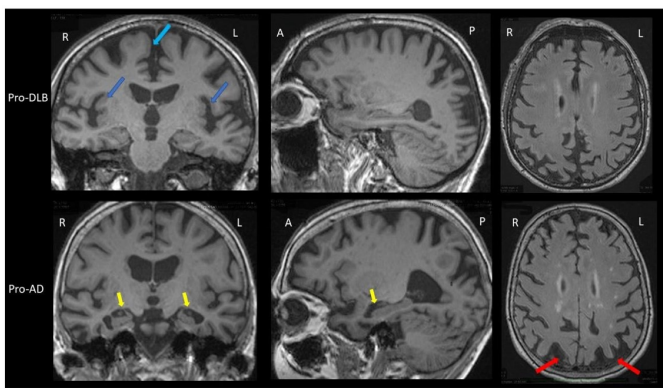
Upper Part: Brain MRI of an 84-year-old prodromal DLB (Pro-DLB) patient. Lower Part: 84-year-old prodromal Alzheimer’s (Pro-AD) patient. Arrows represent areas with gray and white matter degradation. Pro-DLB patient has greater insular atrophy, while the Pro-AD patient shows more pronounced hippocampal atrophy⁷
